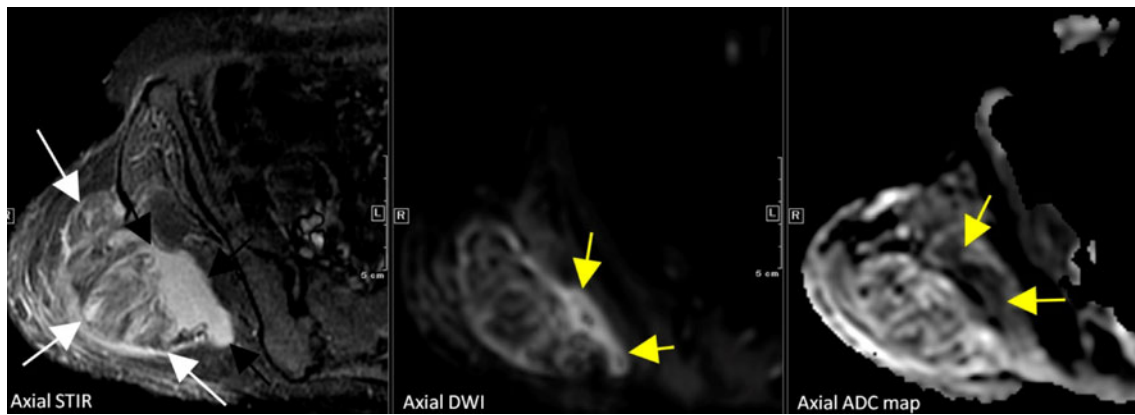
(Case 8): Axial STIR MR image shows edematous subcutaneous fat in the right gluteal region (*white arrows*) and a deep-seated small ill-defined fluid collection (*black arrows*). This fluid collection restricts diffusion with DWI bright (*yellow arrows*) and ADC dark
